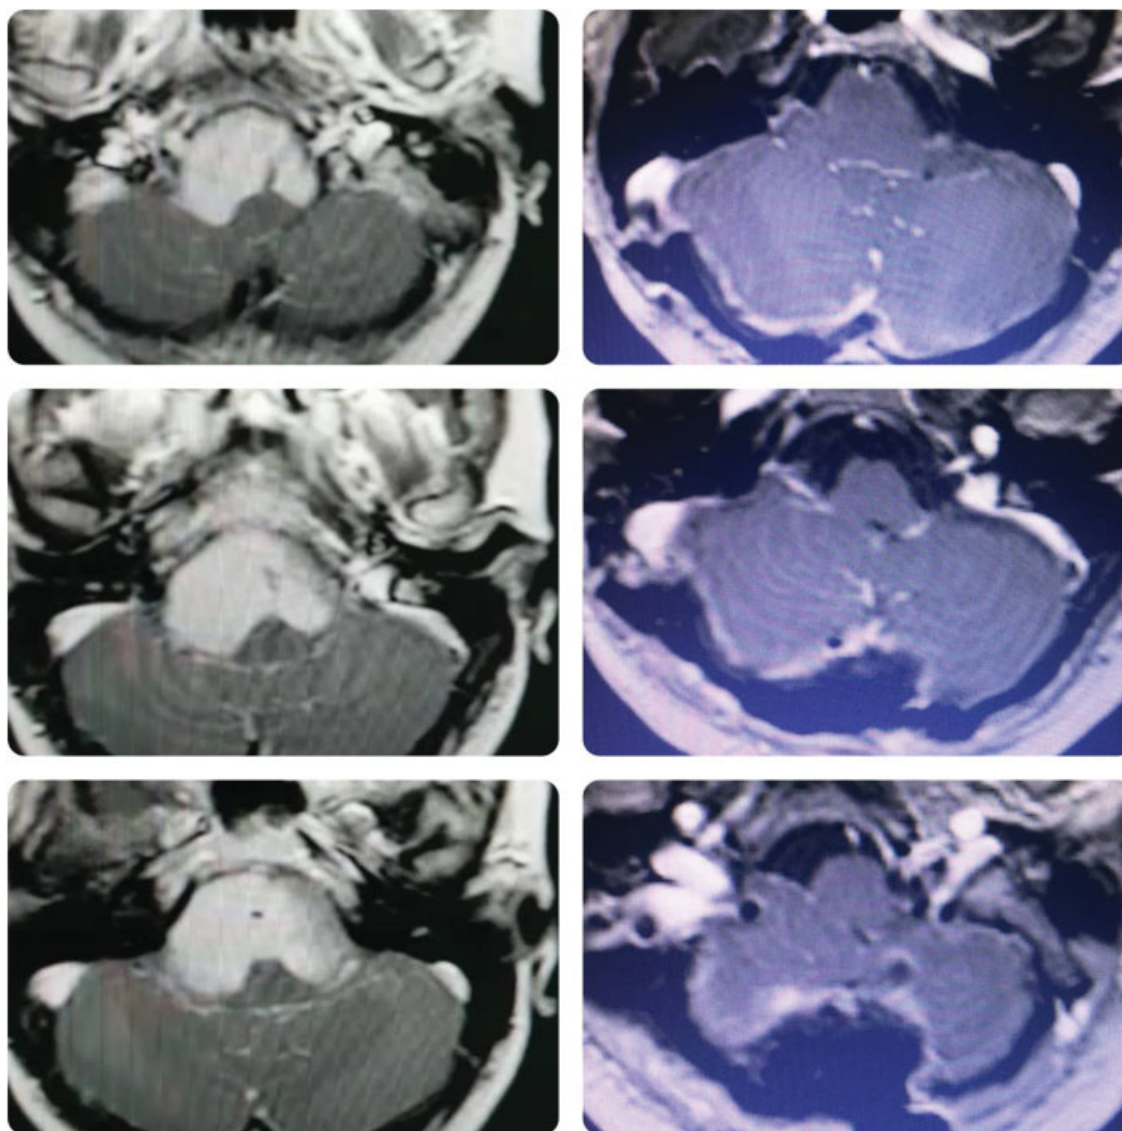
Magnetic resonance imaging scan showing an expansive lesion occupying the posterior fossa (right: preoperative images; left: postoperative images).
